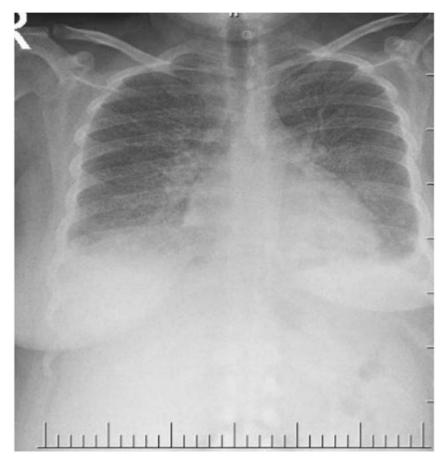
The PA chest radiograph of patient on ED admisson.
